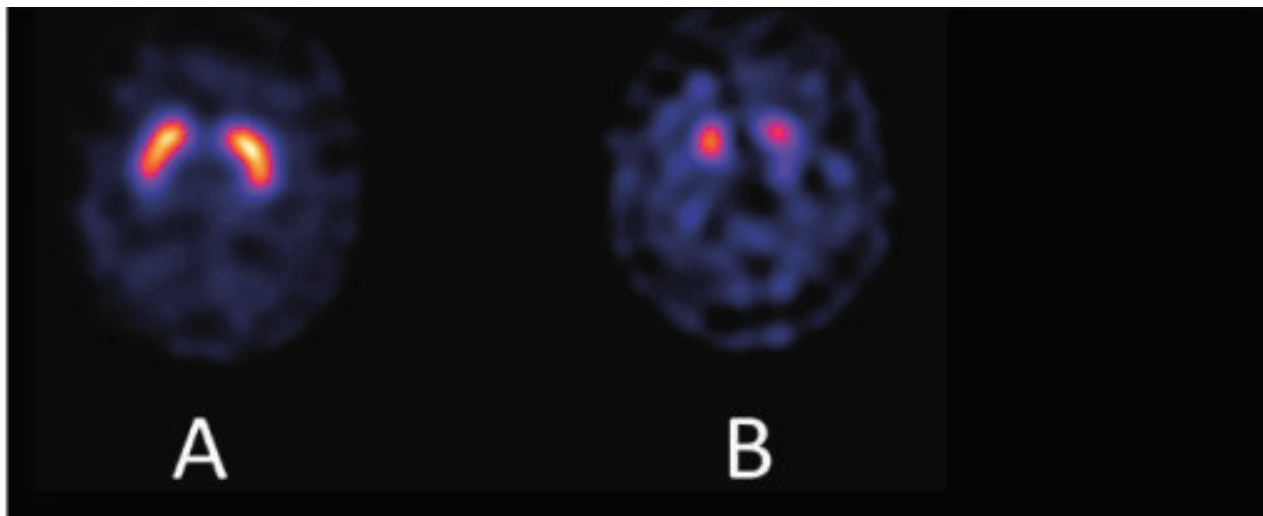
Scans of two patients with parkinsonism. In one case, DaT SPECT shows normal striatal DaT density, virtually ruling out Parkinson's disease or other causes of presynaptic dopaminergic neuron degeneration (A). The second scan shows a patient with Parkinson's disease with marked loss of striatal uptake, particularly in the putamen, and a high level of background activity (B).
